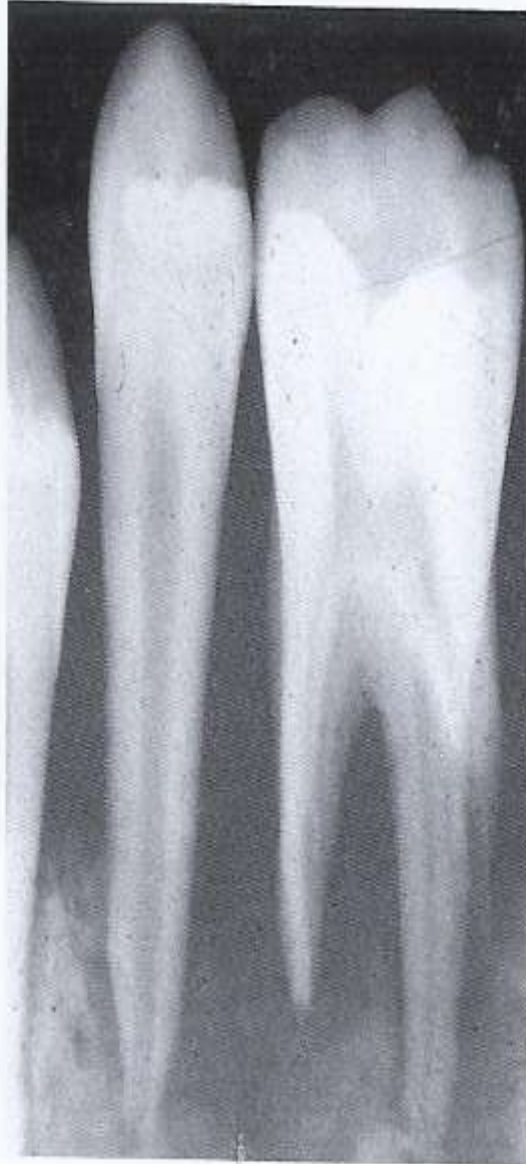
Burkitt's lymphoma: (left) typical appearance resulting from mandibular and parotid involvement; (right) radiograph of the mandible shows characteristic bone destruction and root resorption.
